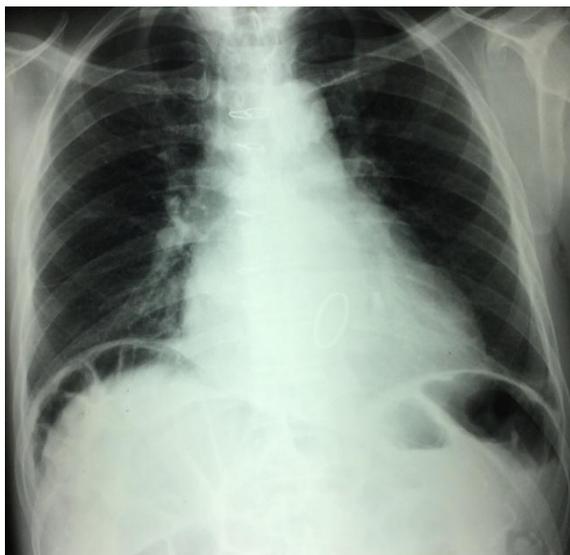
Erect posteroanterior chest radiograph showing hepatodiaphragmatic interposition of small bowel known as Chilaiditi's sign.
